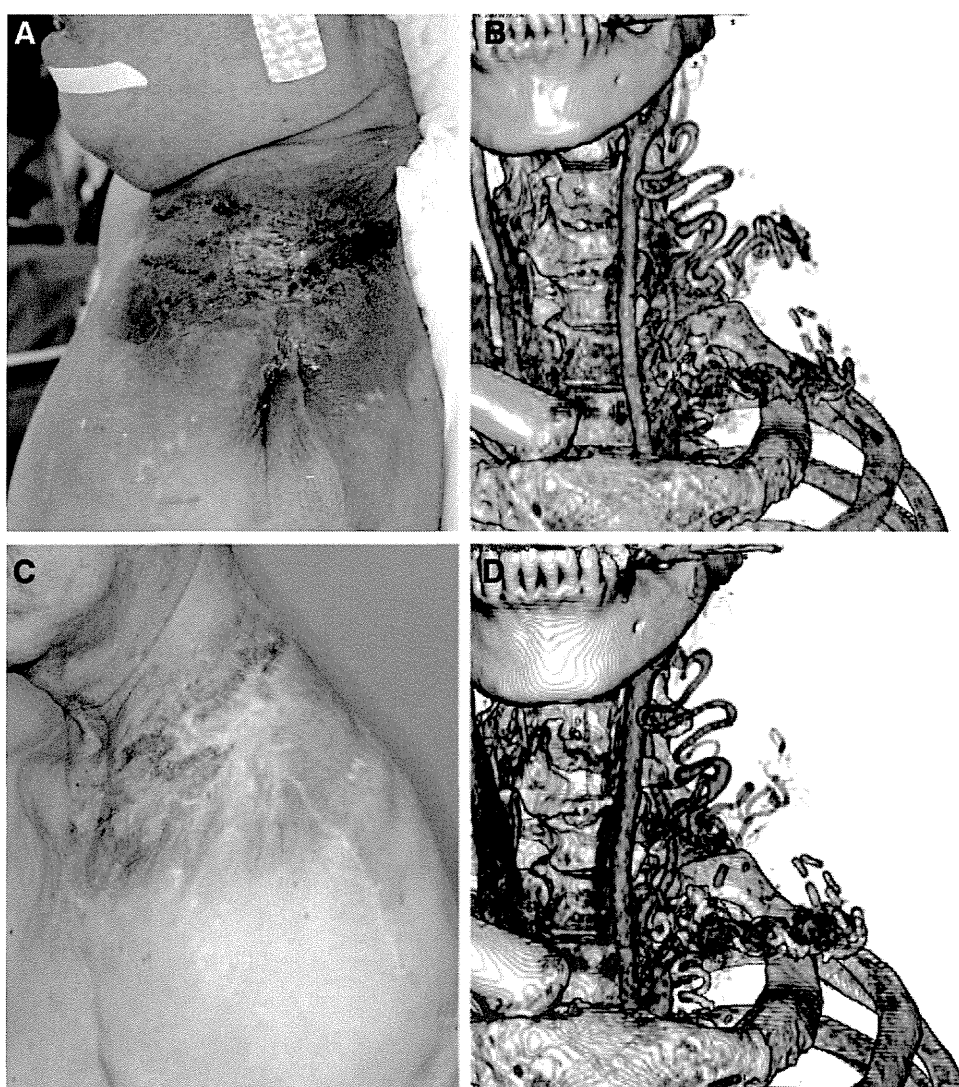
Case 5 (71 years old, male, left shoulder AVM): a representative case in which changes in vascular structure could not be discerned macroscopically, despite symptoms disappeared dramatically with treatment and topological analysis showed normalization of vascular structure. A and B, Preoperative condition and 3D CTA image. The patient was having chronic ulceration and abrupt pulsatile bleeding during sleep. C and D, Six months postoperation. The chronic ulcer has totally epithelized. Macroscopically, changes in vascular structure could not be discerned from CTA.
